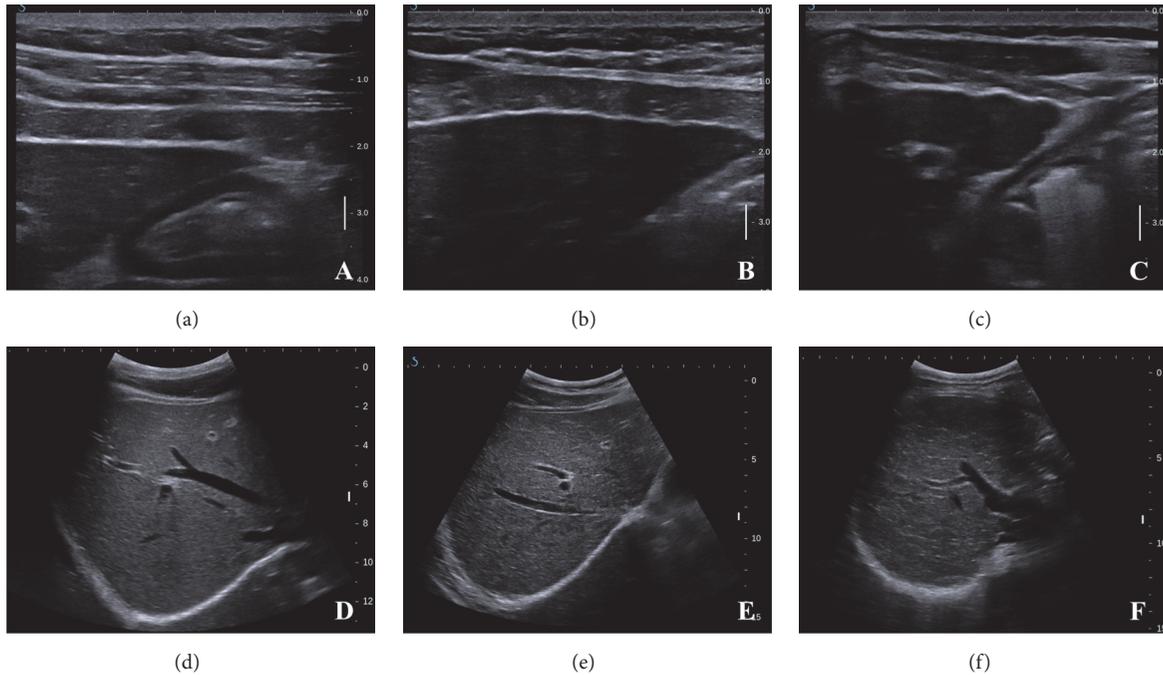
B-mode images of conventional ultrasonography (US) scoring system. (a) Smooth liver surface, score of 1. (b) Uneven liver surface, score of 2. (c) Irregular nodular liver surface, score of 3. (d) Homogeneous parenchyma, score of 1; and smooth hepatic vein vessel wall, score of 1. (e) Heterogeneous liver parenchyma with fine scattered hyperechoic or hypoechoic areas, score of 2. Obscured or slightly irregular hepatic vein vessel wall, score of 2. (f) Coarse liver parenchyma with an irregular pattern, score of 3.
